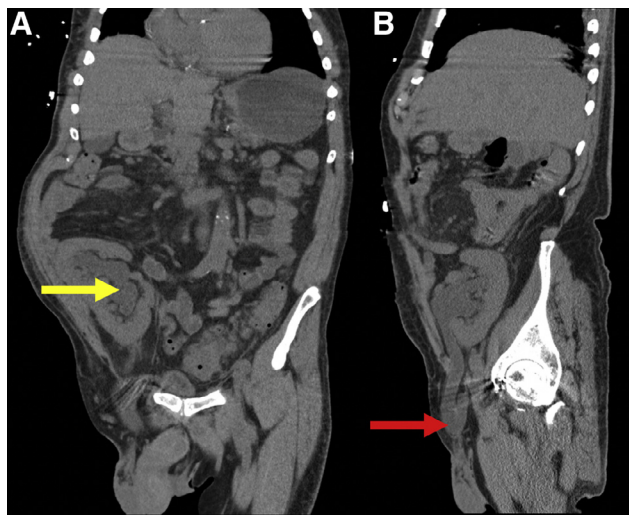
Coronal (A) and sagittal (B) CT without contrast demonstrating moderate to marked hydroureteronephrosis of the right lower quadrant transplant kidney secondary to herniation of ureter into a right inguinal hernia. The yellow arrow points to the dilated renal collecting system. The red arrow points to the dilated transplant ureter within the right inguinal hernia.
